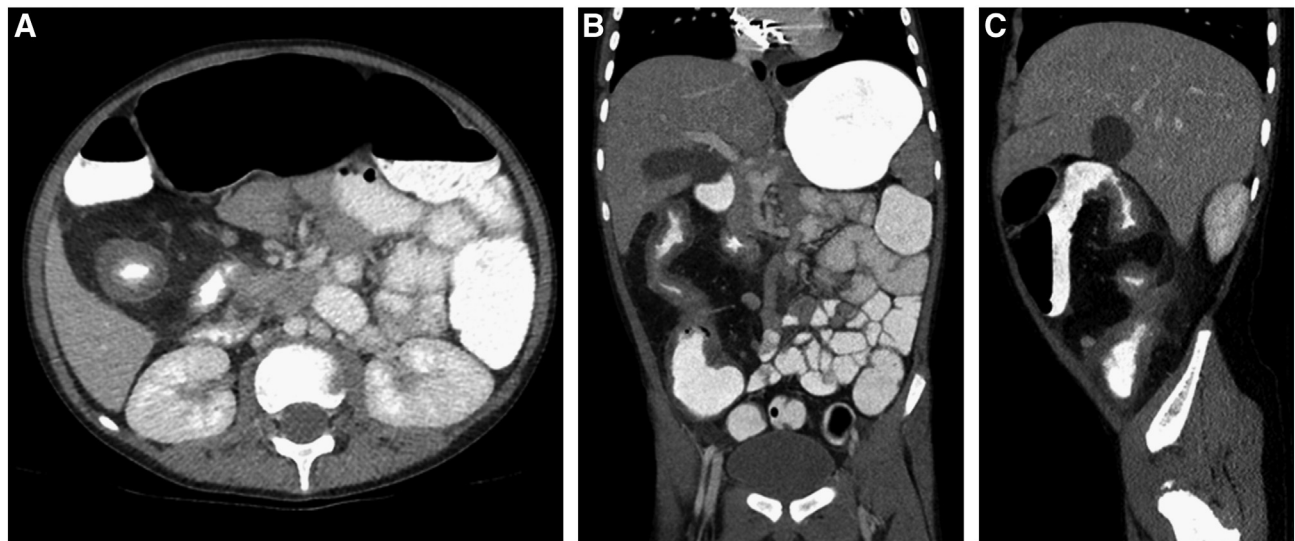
CT scan of the abdomen. Shown are: (A) axial, (B) coronal and (C) sagittal reconstructed images from the abdominal CT scan. Each image demonstrates marked wall thickening of the ascending colon. The surrounding fat is abnormal and more extensive than is seen with Crohn's Disease. In addition, there is stranding within the fat extending from the ascending colonic serosa, the mucosal surface is nodular and irregular, and the lumen of the colon is narrowed with proximal bowel dilation.
